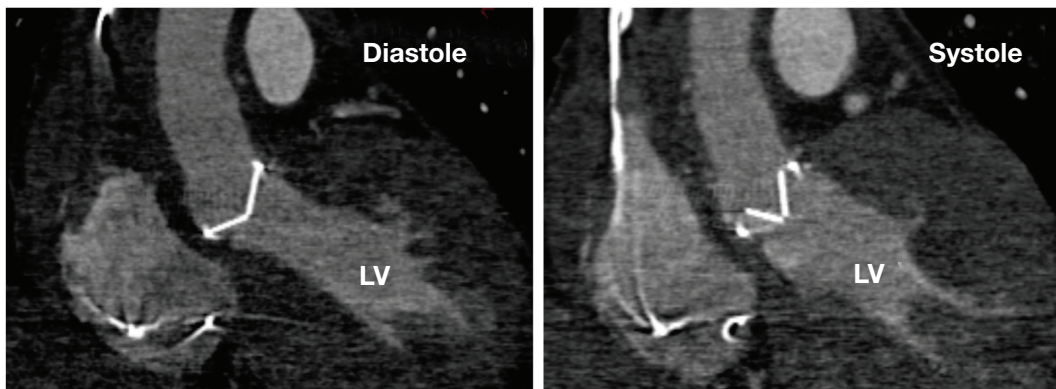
64-slice gated cardiac CT demonstrates partial opening of the valve leaflets in systole without evidence of subvalvular clot or restrictive tissue.
